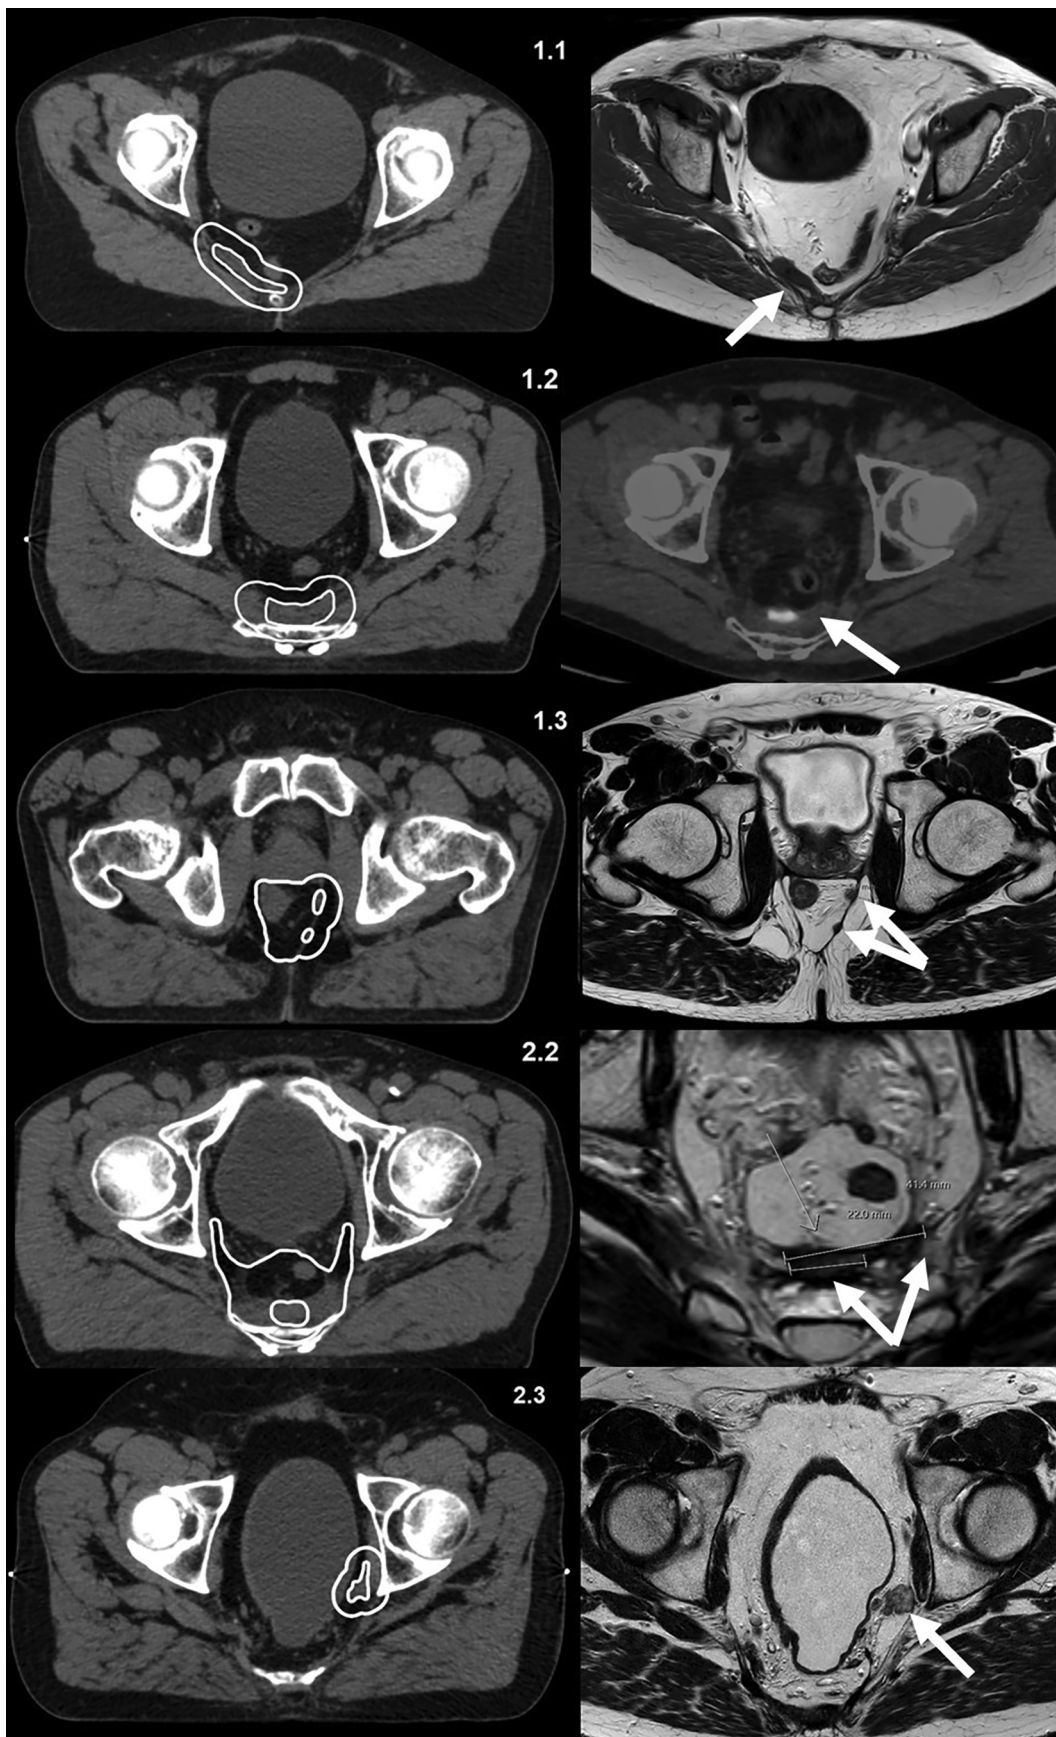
Consensus-based GTV and CTV for cases 1.1–2.3 (on the left), with diagnostic MRI (case 1.1, 1.3–2.3) or PET (case 1.2) imaging on the right. 1.1: Recurrence near the pelvic wall. 1.2 (repeated as 2.1): Recurrence located in fibrosis (with black-and-white PET). 1.3: Multifocal recurrence. 2.2: RT-naïve patient with elective CTV delineation as in LARC. 2.3: Lateral recurrence.
